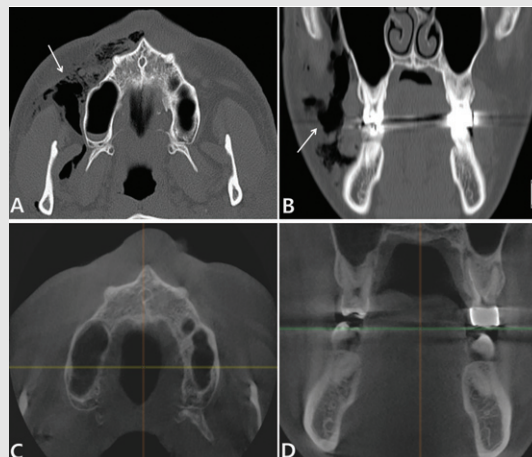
Radiographs taken during the initial examination and 9 days later. A) Subcutaneous air densities (arrow) are present in the right facial area and the right buccal, masticator, submandibular, parapharyngeal, and parotid spaces on facial bone computed tomography (CT) (axial view); B) facial bone CT (coronal view); C) all air densities have disappeared on cone-beam computed tomography (CBCT) (axial view); D) all air densities have disappeared on CBCT (coronal view)
